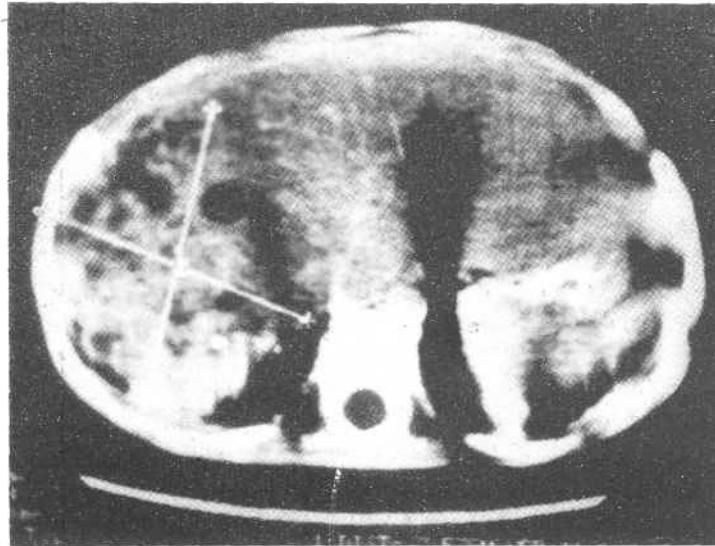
Abdominal CT scan showing the lesion.
